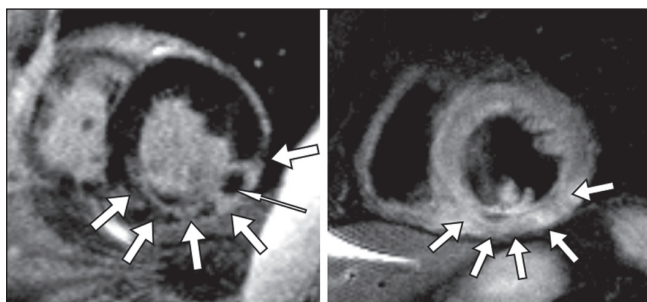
A patient with an acute posterolateral myocardial infarction. The image to the left displays a short-axis view using the 'late enhancement' sequence after application of gadolinium-diethylene triamine penta-acetic acid contrast. There is contrast enhancement indicating myocardial necrosis of the inferior lateral wall (bold arrows), but not in the anterior and septal wall. There is an area of microvascular obstruction, highlighted with the slim arrow. The image to the right is a T2-weighted spin-echo image, showing a regionally high signal in the inferior lateral wall (arrows), consistent with myocardial edema in the area of necrosis. The presence of edema indicates that the infarction is acute
